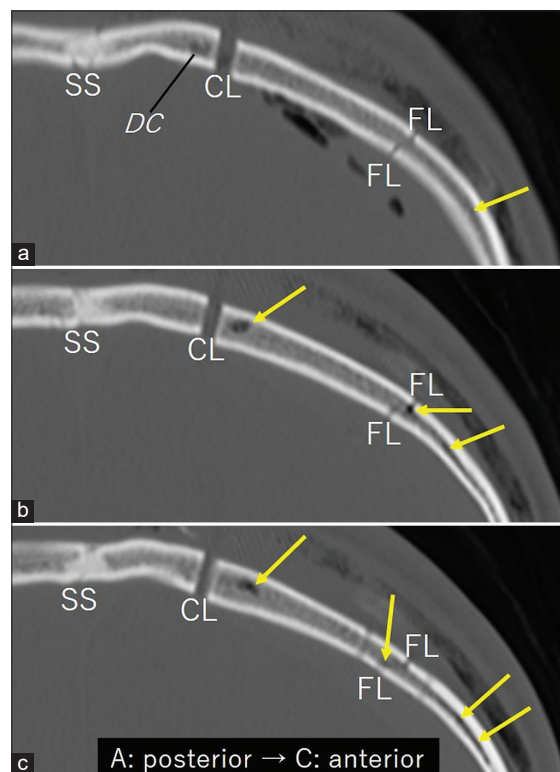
(a-c) Serial bone target coronal computed tomography scans performed immediately after surgery shows the cut of a large diploic channel (DC) by the medial bone cut and other finer DCs lying in the bone flap and exhibiting air density (arrows). CL: craniotomy line, FL: fracture line, SS: sagittal suture.
